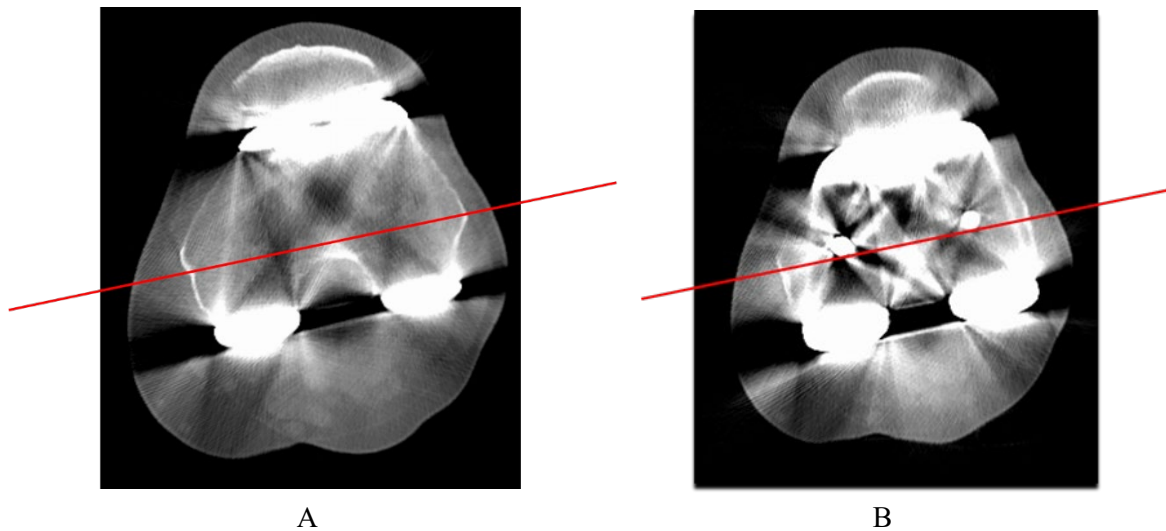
A. The CT derived surgical transepicondylar axis (CTsTEA) is the line drawn from the most prominent part of the lateral epicondyle to the sulcus in the medial epicondyle. B Femoral component rotation is defined by the femoral component rotational axis (FCRA), the common tangent of the two pegs on the inside of the femoral component. Then the CTsTEA from figure 2A was superimposed, and the femoral component rotational angle (FCR-angle) was measured. In this case, the angle was 0°.
